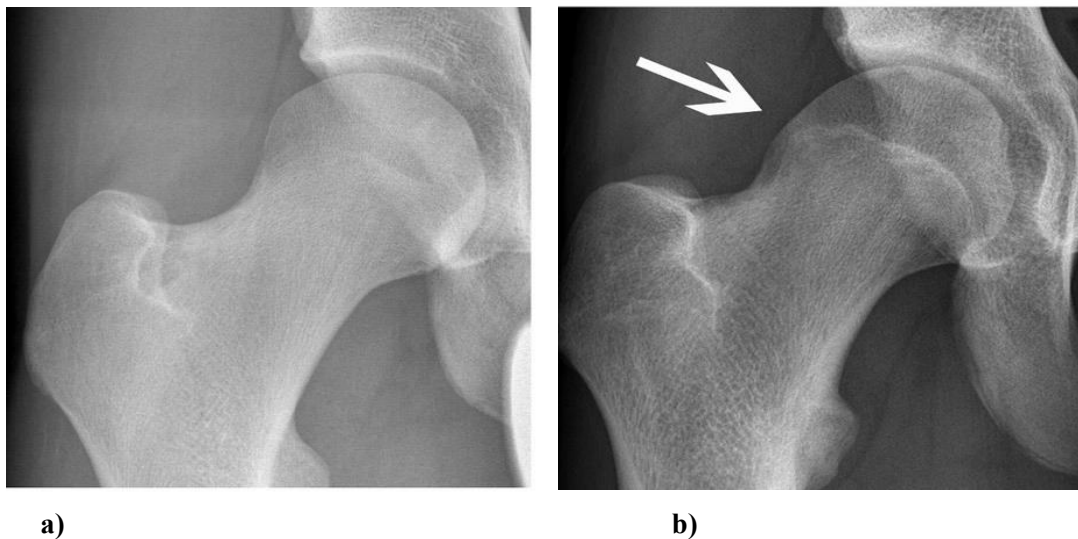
Two anteroposterior radiographs of (a) a normal femur with a convex structure and (b) a femur with a prominence bump at the femoral head neck junction. Adopted from Agricola et al. (17).
